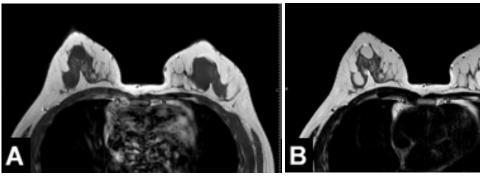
(A, B). Breast cyst on MRI (A – hyposignal T1 and B – hypersignal T2).
